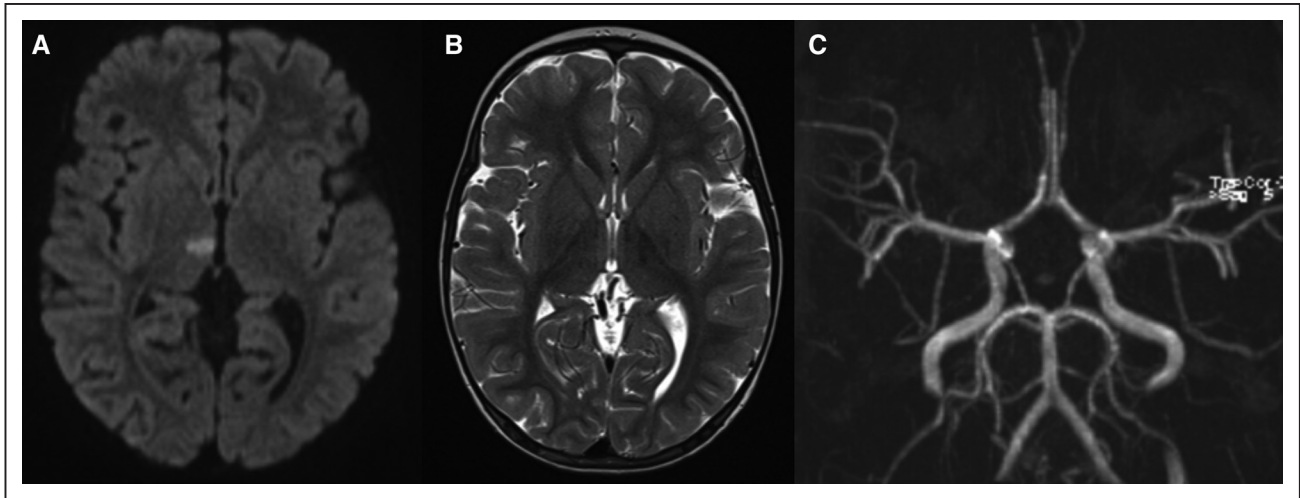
Images from a 2-y-old girl with congenital heart disease (case number 25). Diffusion-weighted imaging (A) revealed an acute right medial thalamic infarction, not yet demarcated, with a normal T2-weighted image (B). Time-of-flight magnetic resonance angiography (MRA) maximum intensity projection reconstruction (C) showed no vessel occlusion, especially patent basilar tip and posterior cerebral artery on the right. The absence of vessel irregularity, stenosis or occlusion on MRA, and the clinical history suggested a thromboembolic event.
